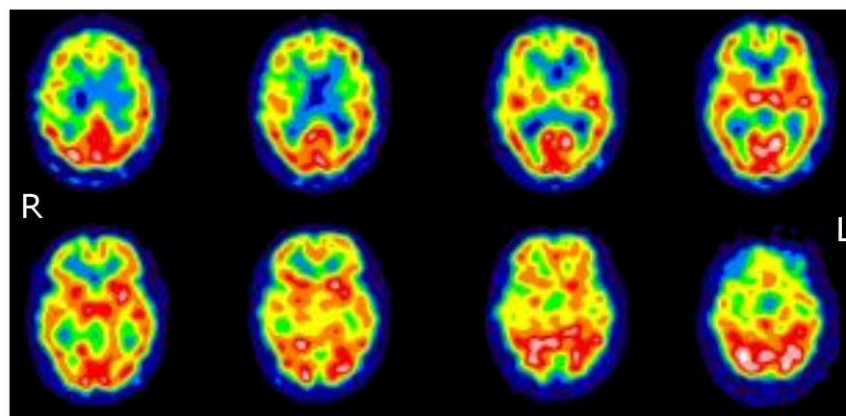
SPECT scans for NB. Axial slices for NB taken in July 2014 and August 2015. R=Right, L=Left
